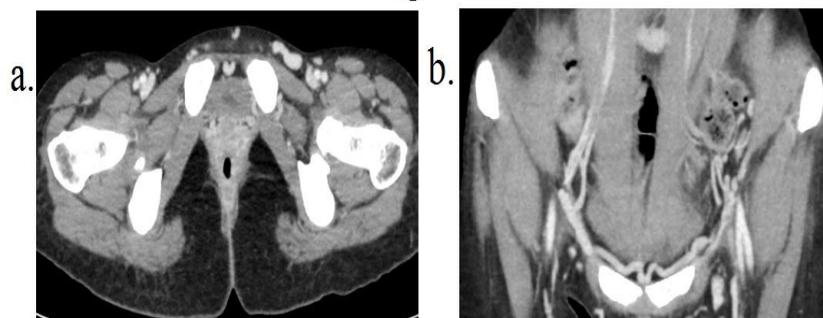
Axial and coronal contrast CT showing collateral veins in the anterior abdominal wall and in the pelvis.
